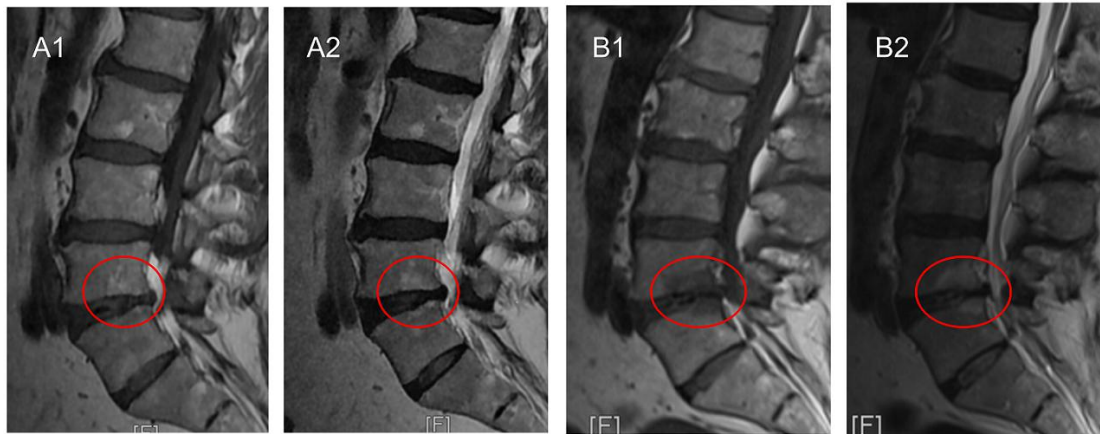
New Modic changes at the adjacent level. A. Modic type 2 change (MC2) with hyperintense both on T1- (A1) and T2-weighted images (A2) was detected at the surgical level (L5/S1) on the preoperative magnetic resonance imaging (MRI) scanning. B. Postoperative MRI was with evidence of new MC2 (hyperintense both on T1- (B1) and T2-weighted images (B2)) at its adjacent level (L4/5) and the volume of preexisting MC2 at the level of L5/S1 significantly increased after surgery.
